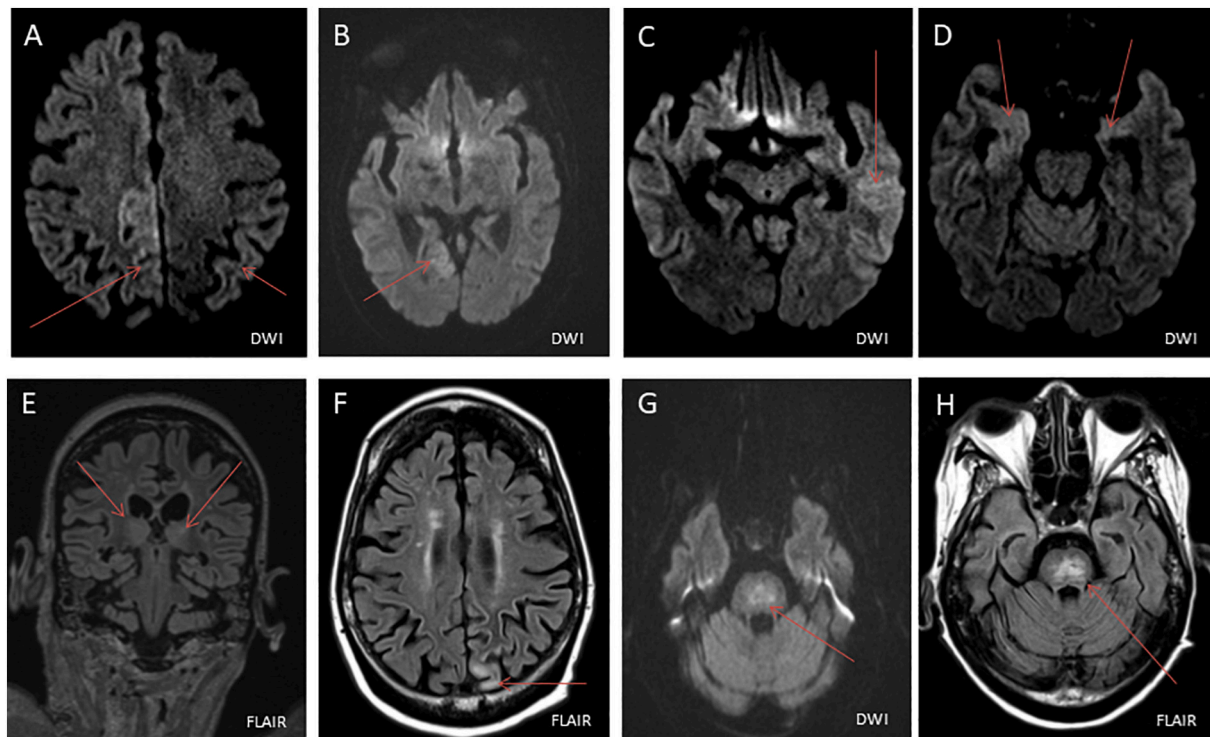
Different MRI sequences demonstrating exacerbation of the previously seen lesions in Fig. 1 as well as the appearance of newer lesions. As seen, the lesions are cortical and subcortical. Images A-D shows new restricted diffusions in disseminated locations. Image E shows bi-thalamic mild hyperintensities on FLAIR which were not present in Fig. 2 Image F that demonstrated resolution of these lesions. Image F demonstrates a new FLAIR lesion in the left occipital cortex. Images G and H demonstrate the reappearance of the pontine lesions.
